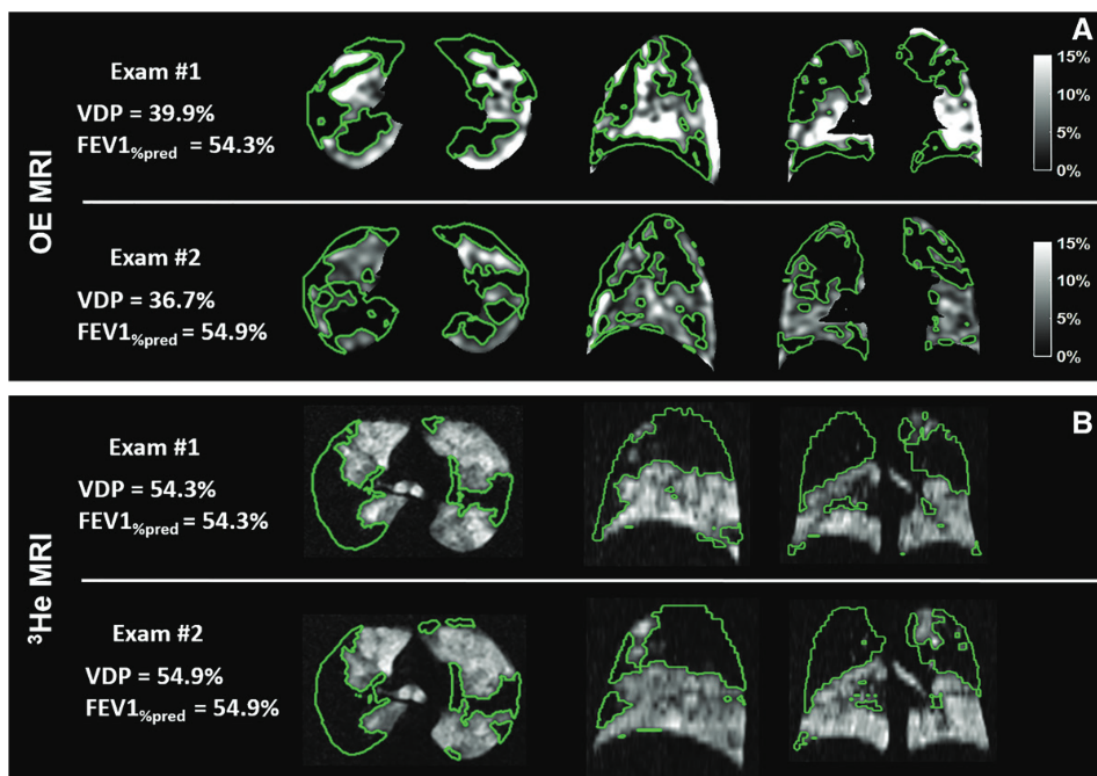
The repeatability of ventilation defect percentage (VDP) was assessed using oxygen-enhanced MRI and hyperpolarized ^3He MRI in a 37-year-old woman with cystic fibrosis. The examinations, conducted a week apart, showed a similar VDP despite slight variations in spatial locations of large focal defects outlined in green. Defects regions are consistent between techniques but not their surfaces. The average Dice coefficient¹³⁷ for regional defects between examinations was 0.48 for oxygen-enhanced MRI and 0.72 for ^3He MRI, indicating better repeatability with ^3He MRI. The Figure is extracted from Zha *et al.*¹³⁸
